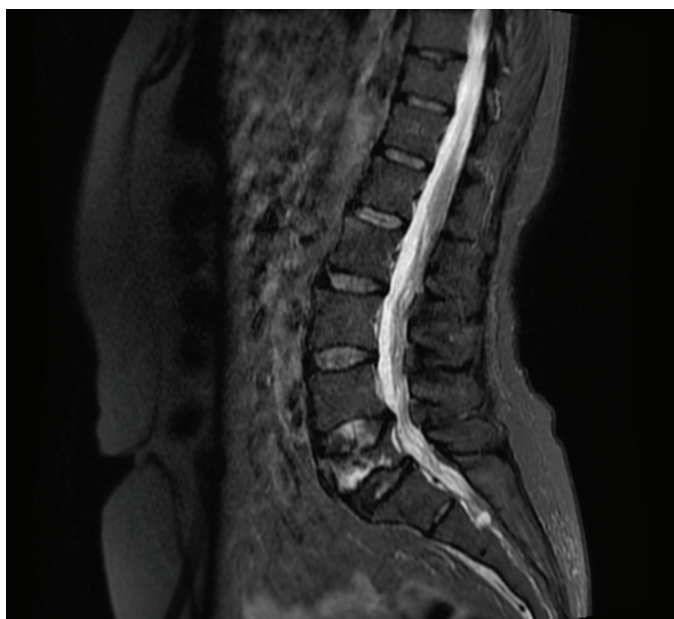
The preoperative MRI images of the patient with breast cancer
